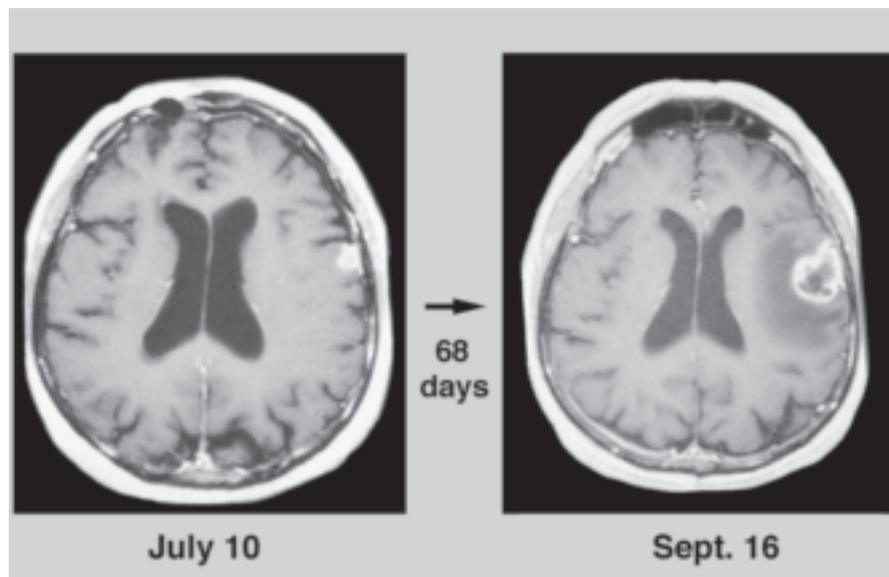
An MRI scan of a primary glioblastoma in a 79 year-old patient. A small cortical lesion rapidly developed into a full-blown glioblastoma with perifocal oedema and central necrosis.
